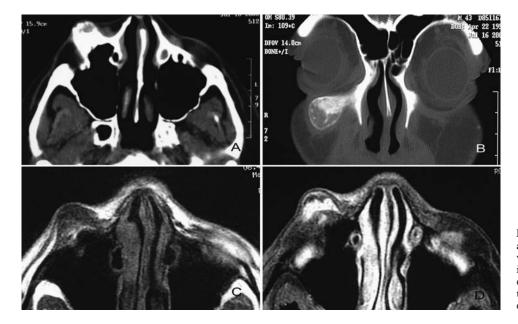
(A,C,D) Axial CT and MR images of focally sclerotic, well-delineated tumor of the inferior orbital rim. (B) Bone window study shows well-delineated tumor with intralesional deposits of young bone.
